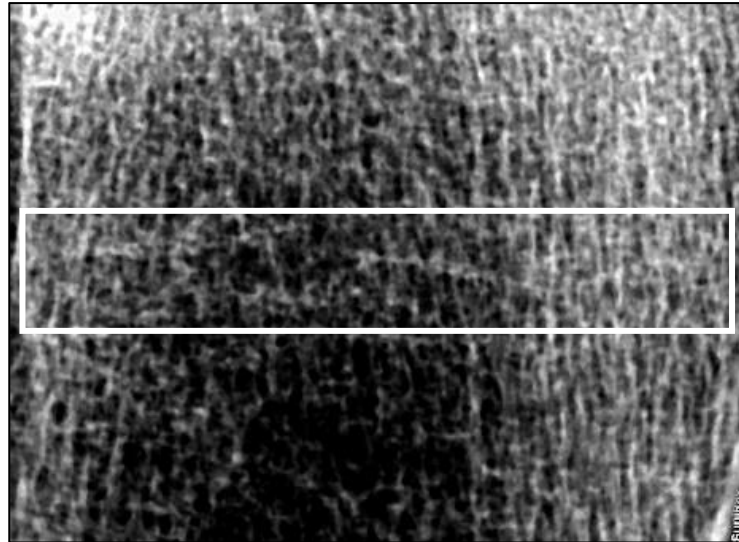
Harris lines visible on a radiograph of the left distal tibia of individual 134, an adult male from the Scar boat burial.
